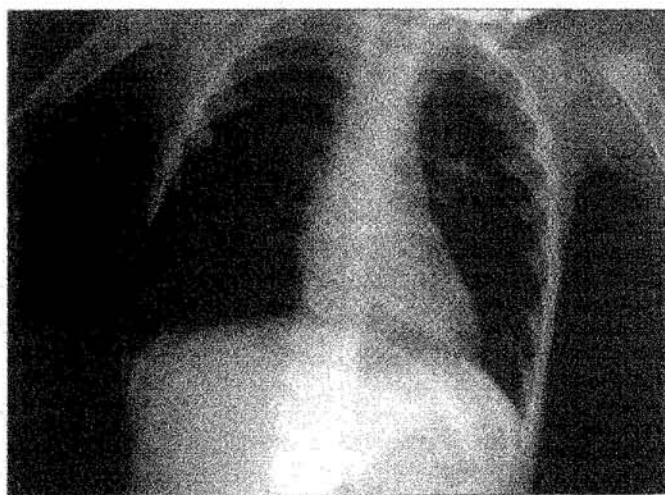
Follow-up frontal chest x-ray of Case 1 showing asymmetrical hypertranslucency of left lung and depressed left diaphragm
